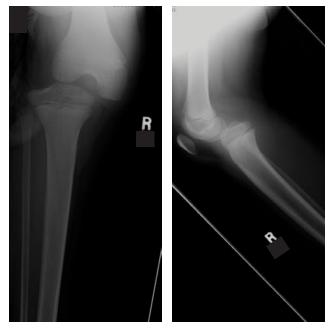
Anteroposterior x-ray of knee.
